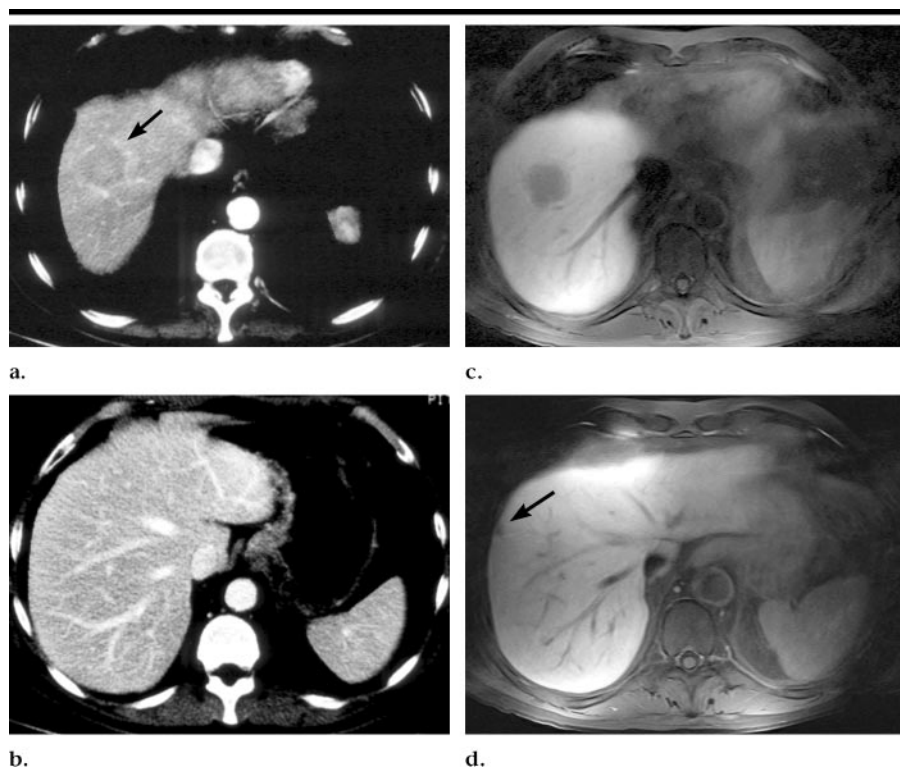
Images of a 57-year-old man. (a) Transverse helical CT scan near dome of liver shows approximately 3-cm lesion owing to metastasis (arrow). Lesion was not detected by two of three readers. (b) Transverse helical CT scan several centimeters below a was interpreted as negative for tumor by all three readers. (c) Delayed postcontrast transverse T1-weighted MR image (200/4.4) at same level as a shows hypointense lesion owing to metastasis. Lesion was detected by all readers. (d) Delayed postcontrast transverse T1-weighted MR image (180/4.4) at same level as b shows 1-cm lesion (arrow) that was confirmed as metastasis. Lesion was detected by two of three readers. Differences in breath holding account for slight differences in image levels.
